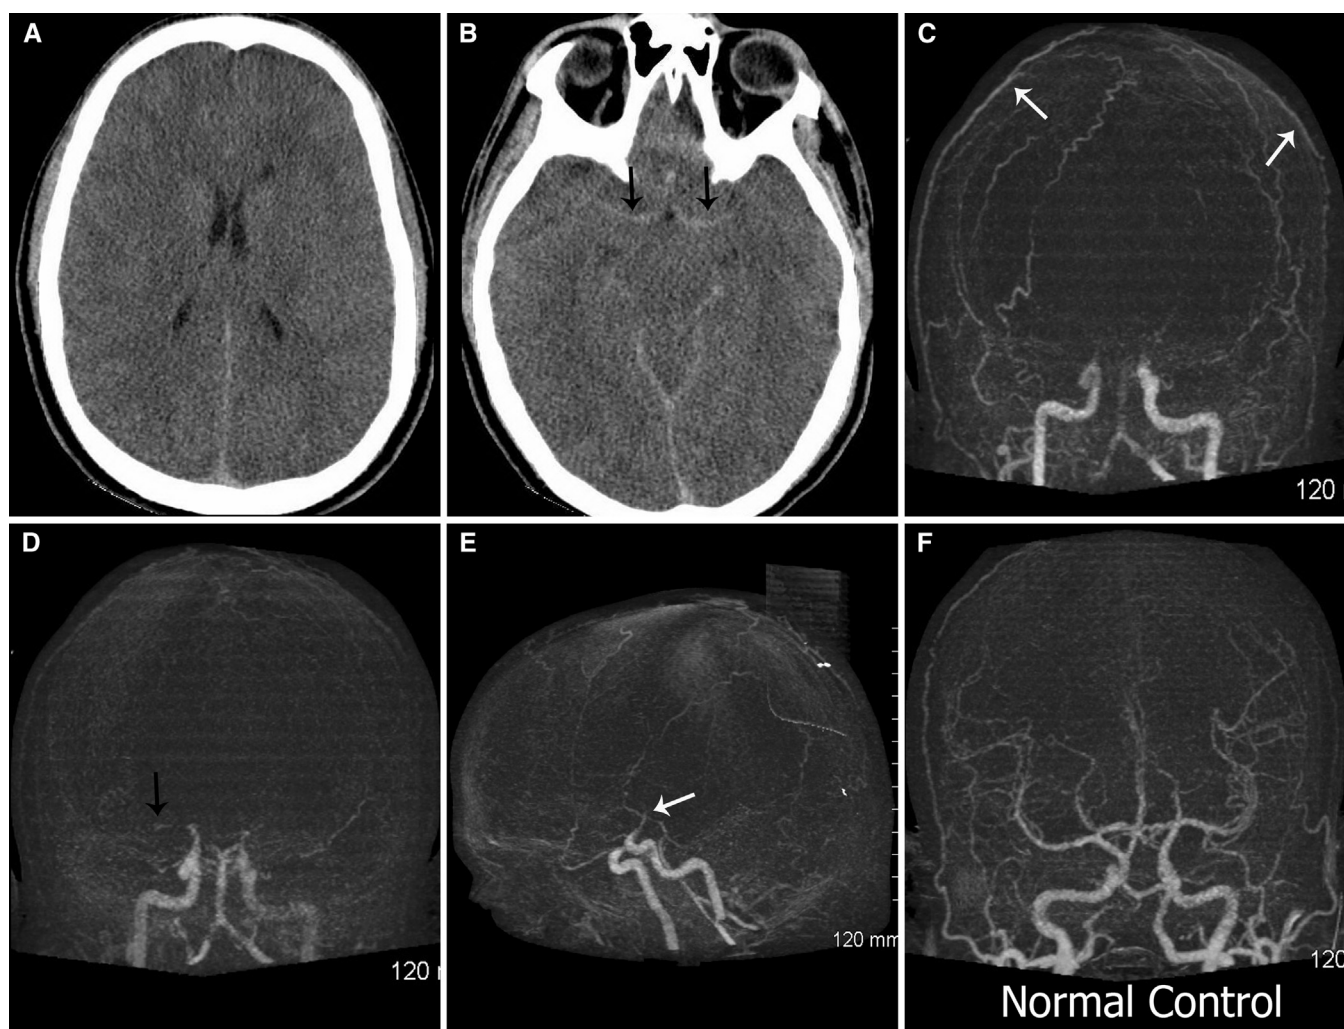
(A, B) Noncontrast computed tomography (CT) of the head, showing subtle loss of grey-white matter differentiation, brain swelling (A), and pseudo-subarachnoid hemorrhage (B) (black arrows). (C) Frontal view dynamic CT angiography at 24 seconds, showing delayed filling of the basilar artery and bilateral internal carotid arteries (ICA) at the skull base but no filling of the distal branches. Filling of the superficial temporal and external carotid branches (white arrows) are noted, which is helpful as an internal reference. (D) Frontal view at 28 seconds, showing minimal filling of the right M1 segment (black arrow) and no filling of the bilateral distal middle cerebral artery and posterior cerebral artery branches. (E) A lateral view at 24 seconds, showing abrupt tapering of the ICAs at the skull base (white arrow), a typical angiographic feature of brain death. (F) A normal control with simultaneous filling of intra- and extracranial branches.
